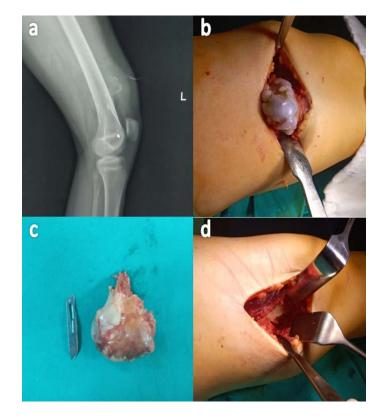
The radiograph (a) and peroperative images (b,c,d) of a patient who underwent total excision
